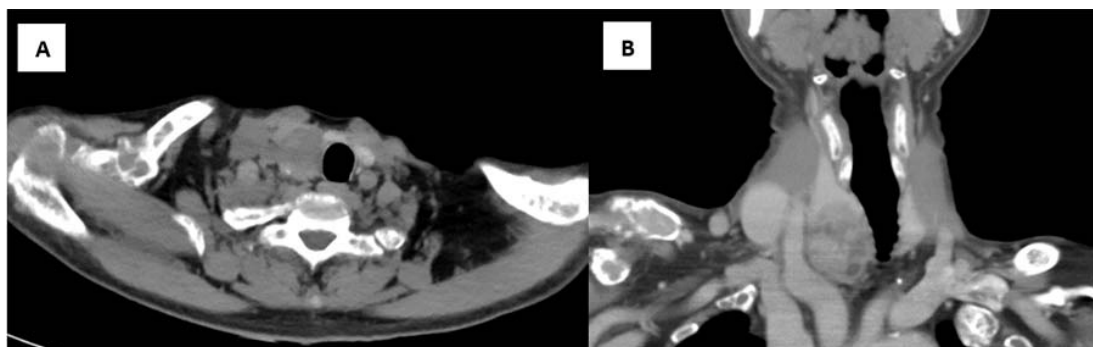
CT Neck with the contrast of parathyroid carcinoma; (A) Axial view. (B) Coronal view. Findings: well-defined heterogeneous hypervascular lesion at the lower aspect of right thyroid gland size 2.9x3.2x3.7 cm, no cervical lymph node enlargement
